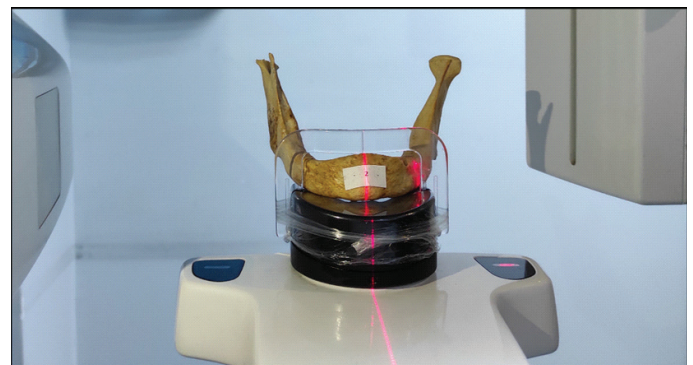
Positioning of dry human mandible for panoramic radiograph.
